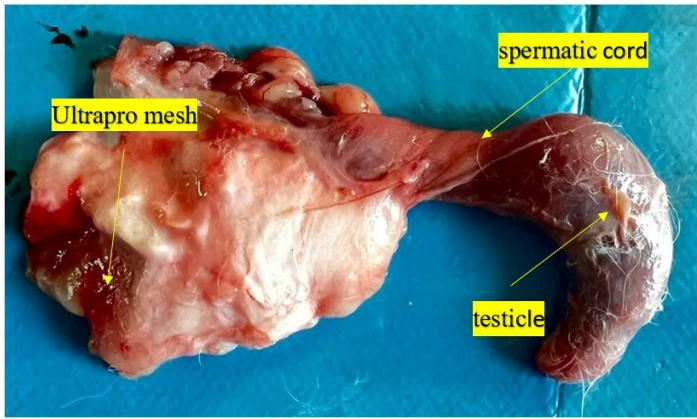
Resected inguinal canal including testis following injection of the X-ray solution
